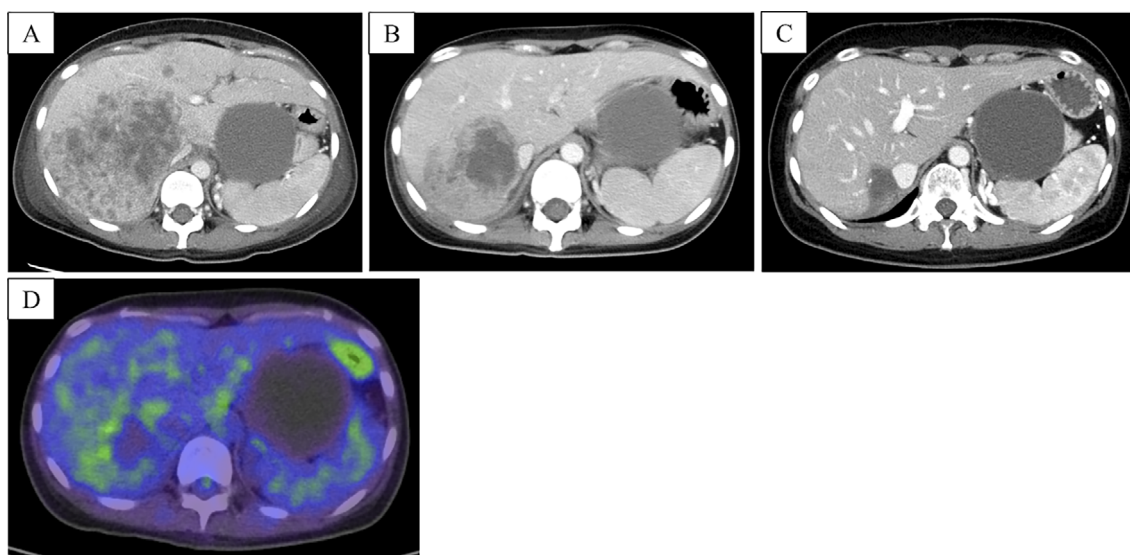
Abdominal computed tomography before chemotherapy (A), after 2 courses of chemotherapy (B), and after 10 courses of chemotherapy (C). Fluorodeoxyglucose-positron emission tomography/computed tomography after 3 courses of chemotherapy (D) showing a significantly shrunken tumor in the right lobe of the liver (maximum standardized uptake value: 2.94).
